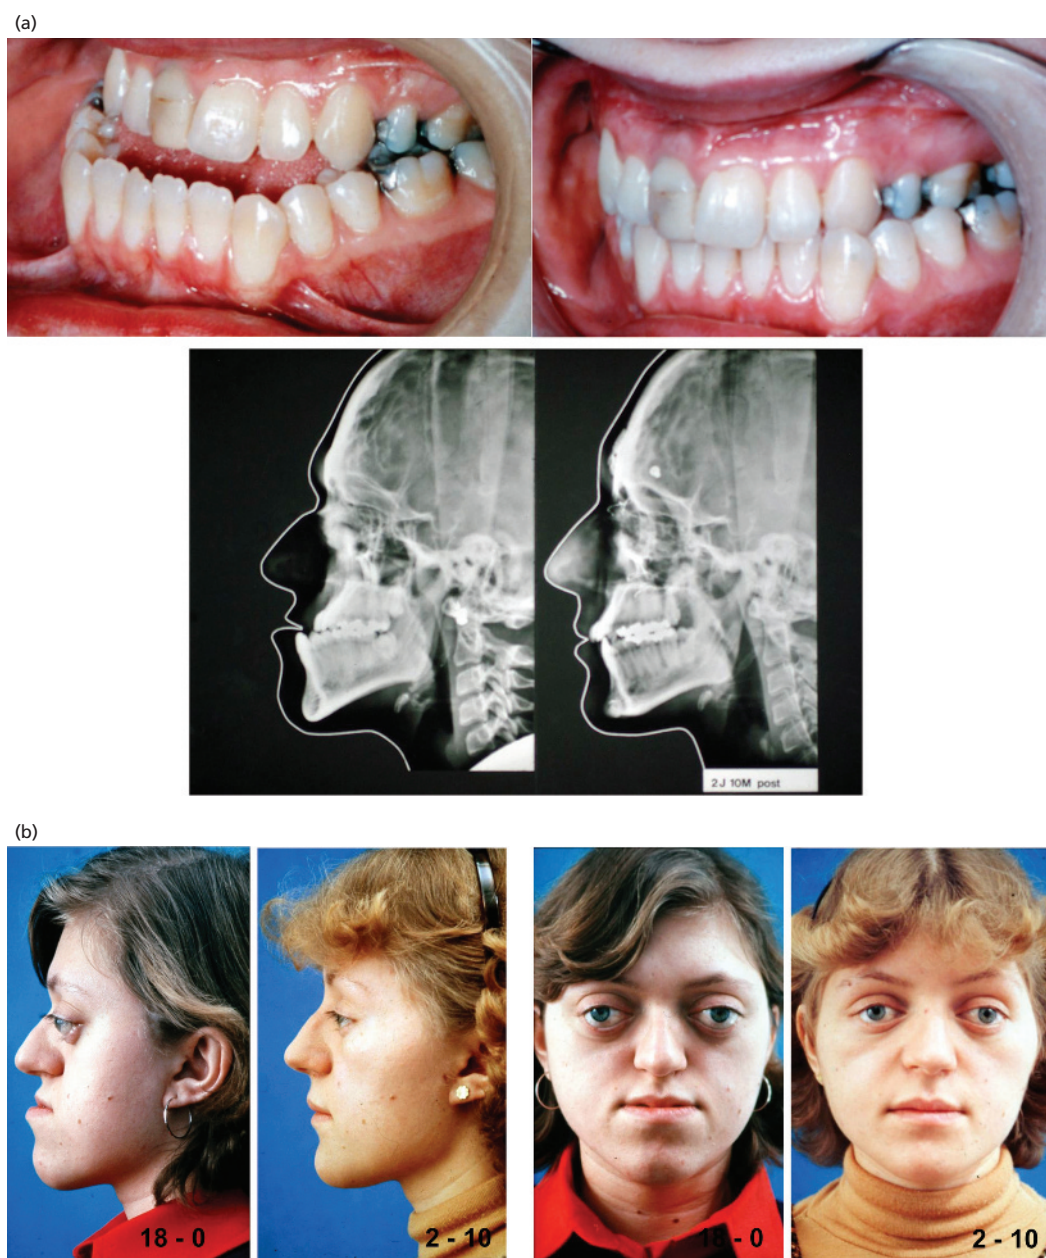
Case of micro-retromaxillism: (a) Occlusion and lateral skull radiographs before and after surgery; (b) Profile and front views of case before and 2 years and 10 months after surgery. (From: Obwegeser HL. *Mandibular Growth Anomalies*. Springer, 2001.)³¹
